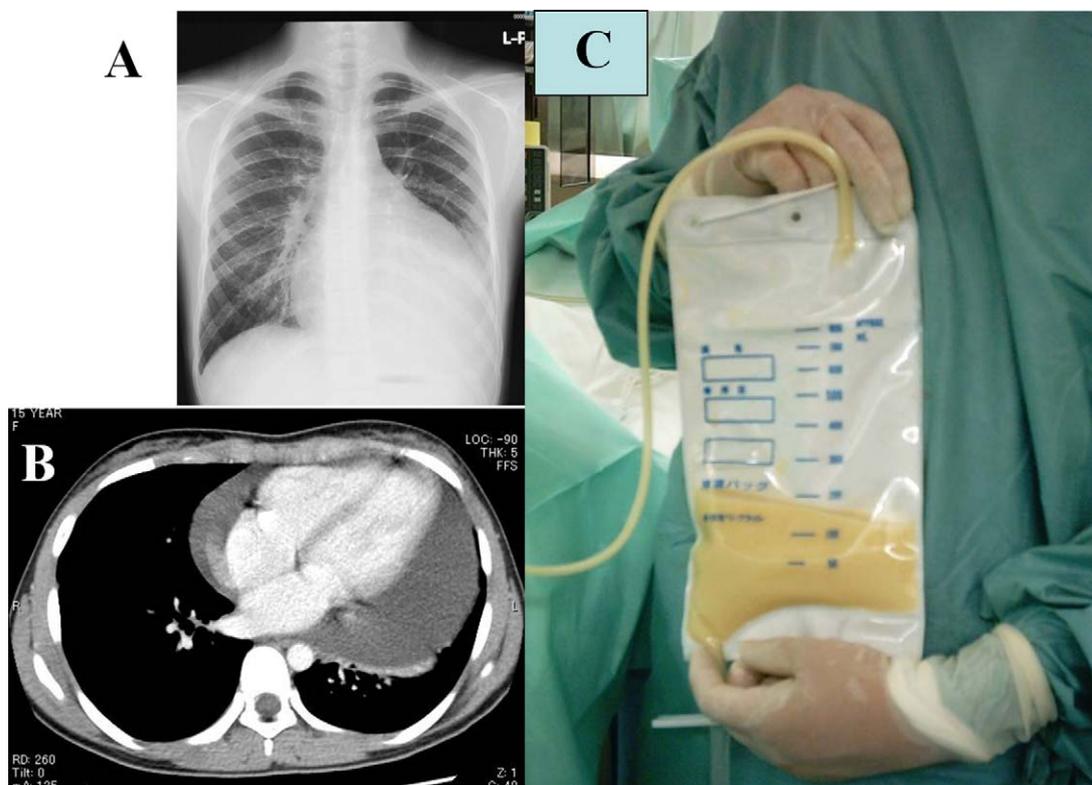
(A) A chest X-ray shows an enlarged cardiac silhouette. (B) Computed tomography demonstrates massive pericardial effusion. (C) 1100 ml of chylous fluid was drained.
